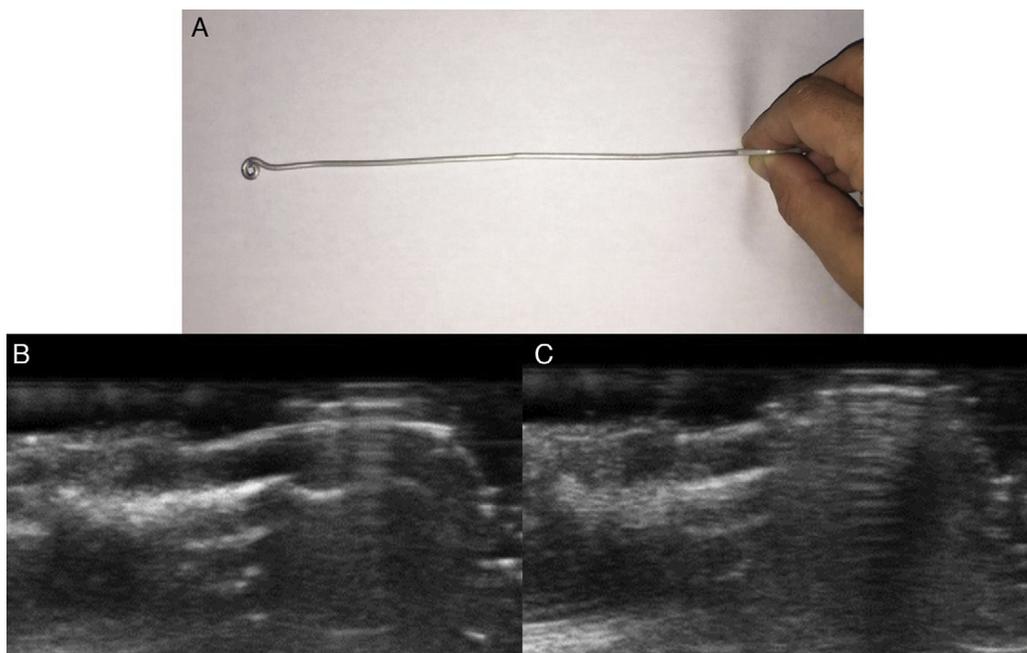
A, Homemade metallic ultrasound guide. B and C, Use of comet tail reverberation to create an ultrasound guide for preoperative localization.
